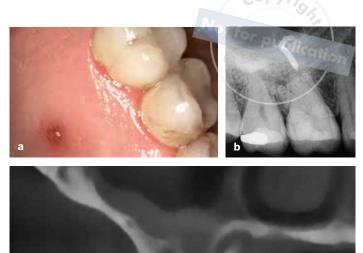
Sinus tracts indicate a draining infection, and radiographs must be used to confirm their source. Both periapical imaging utilizing a gutta-percha cone for tracing or CBCT imaging to accurately show the pathology and its tract through bone to soft tissue are acceptable options. In the case shown, a palatal sinus tract (a) was traced to the maxillary right first molar first with gutta-percha and periapical imaging (b) and then via CBCT imaging without tracing (c).
